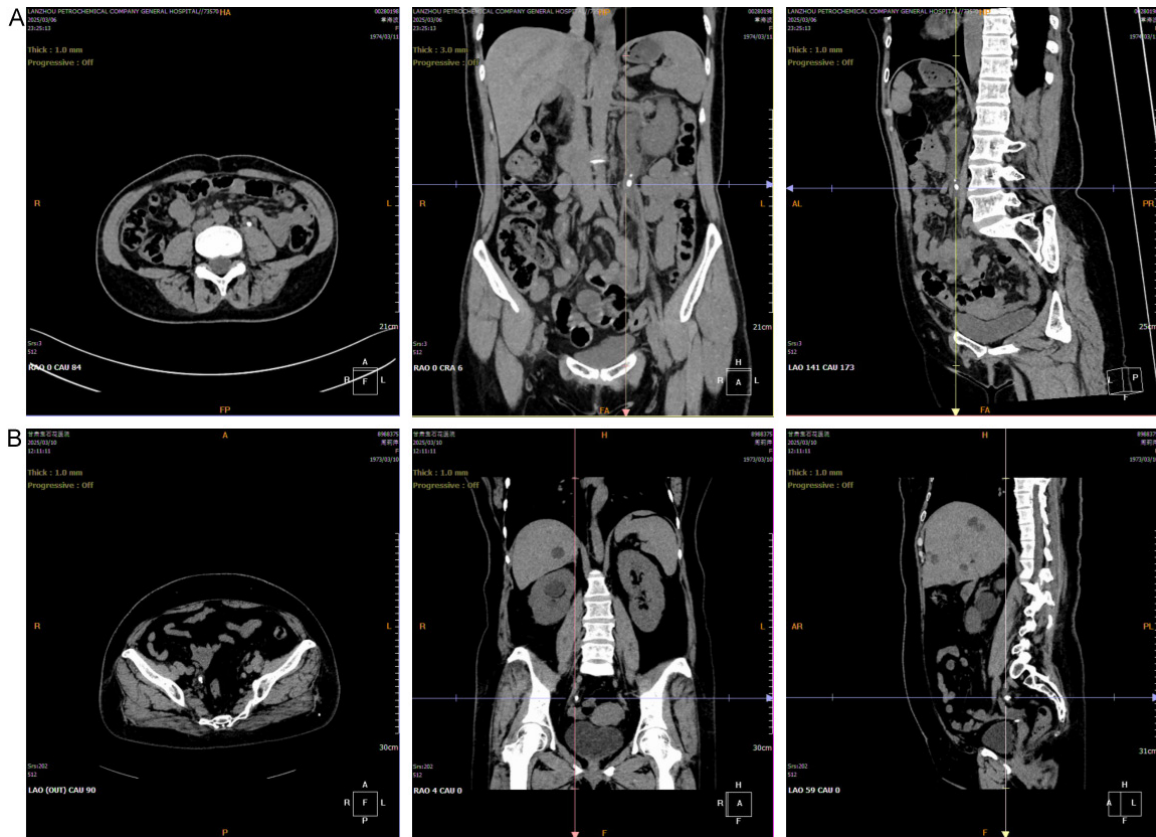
Representative dual-source CT images of two urinary stone patients. A: Female, 51 years old. Axial, coronal, and sagittal reconstruction images demonstrate a stone located in the right upper urinary tract (ureter/renal pelvis region), appearing as localized high-density shadow. B: Female, 52 years old. Axial, coronal, and sagittal reconstruction images show a stone in the lower urinary tract (bladder/distal ureter region), presenting as a localized high-density shadow.
